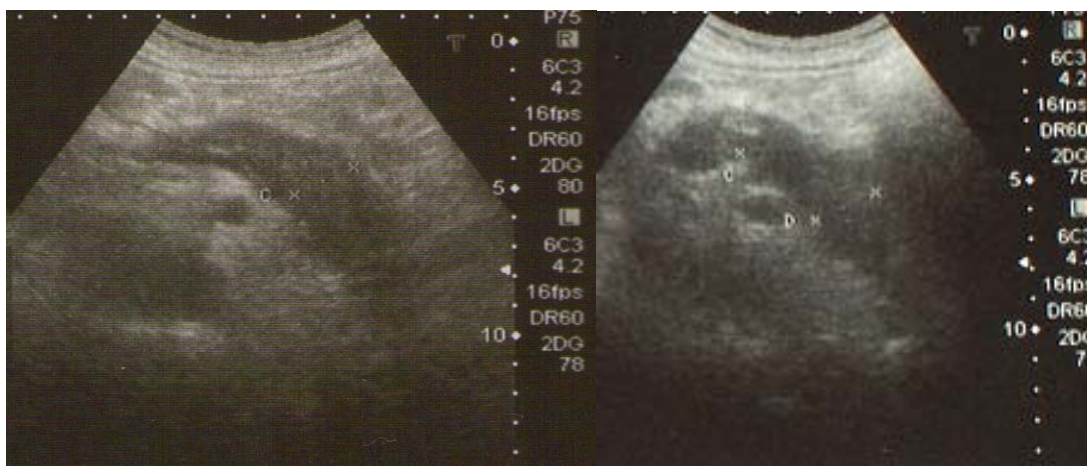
Ultrasound of the abdomen showing the voluminous hypoechoic pancreas.
